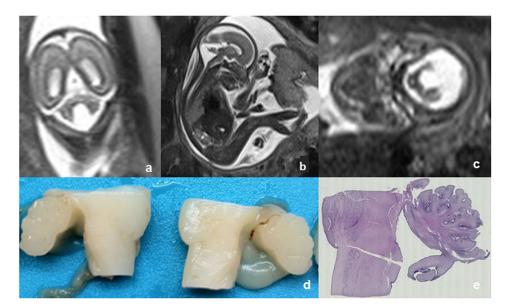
Fetus at 22 weeks of gestation + 3 days. Magnetic resonance imaging shows the diastasis of cerebellar emispheres associated to the agenesis of the inferior part of the vermis (a–c) with an enlarged cisterna magna (b); fastigium and primary fissure are not visualized. Sagittal section of the vermis shows dorsal rotation, widening of the tegmento-vermian angle, flat fastigium and enlarged fourth ventricle (d). Dysmorphic appearance of posterior lobe, with simplified uvula, thick and elongated nodulus describing the appearance of a 'tail' (e). These findings are in accordance with 'Dandy–Walker malformation'
